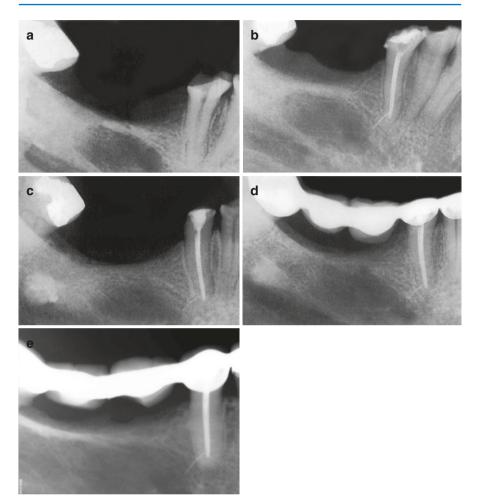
(a) Preoperative radiograph of a mandibular premolar. (b) Immediate post-obturation radiograph where a fragment protruding into the periapical area can be seen. (c, d) Healthy periapical tissues can be seen at recall radiographs at 6 weeks and 3 and 19 years, respectively (Reprinted and modified with permission from Lambrianidis 2001)
